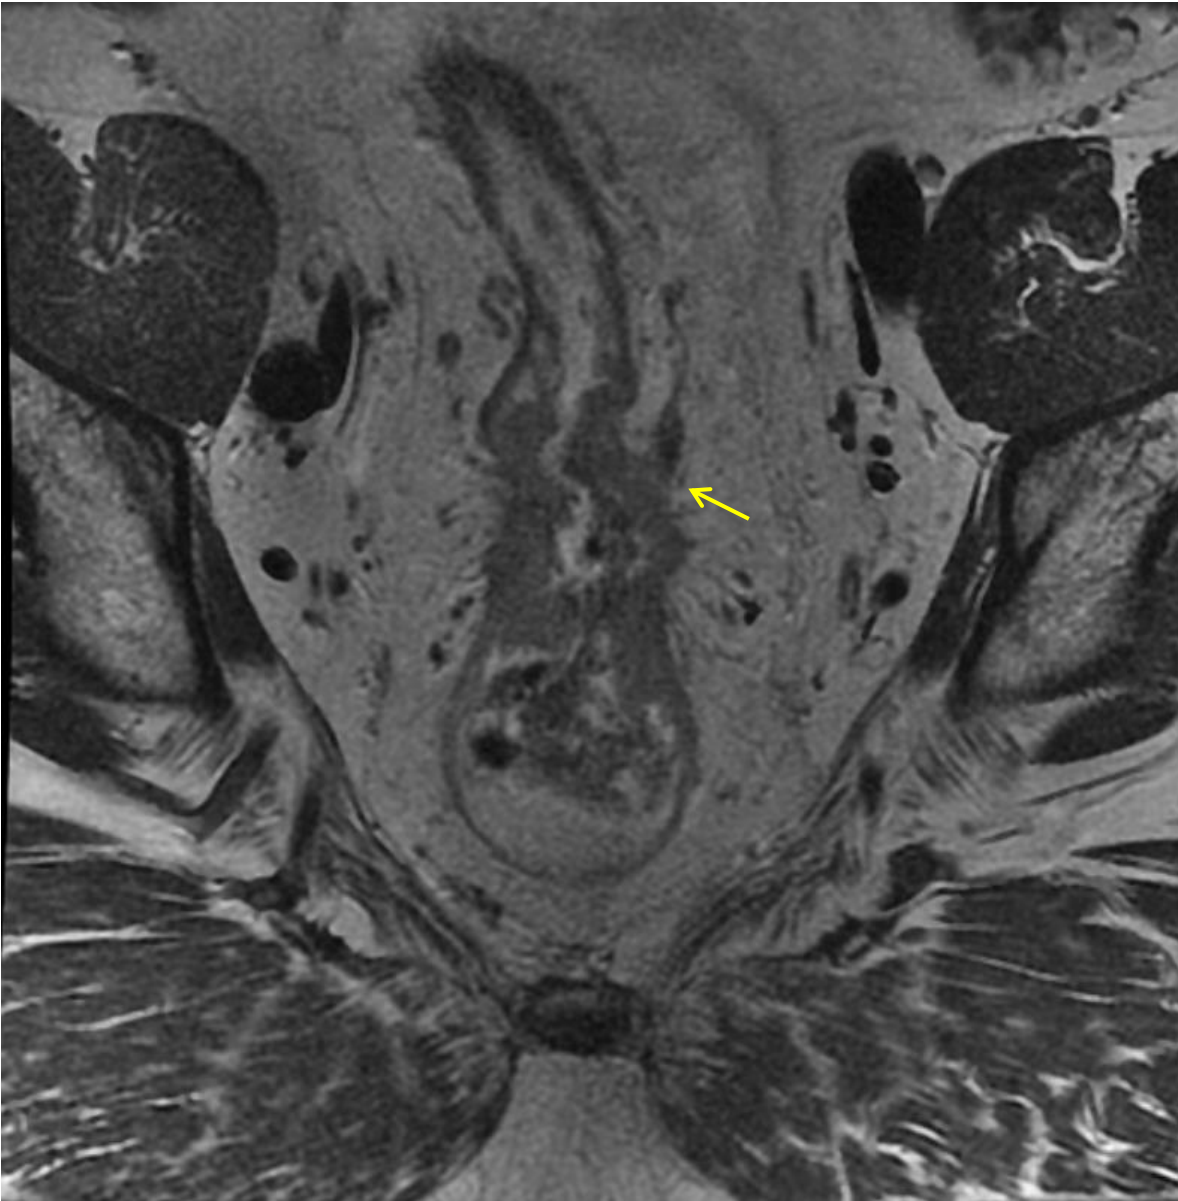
(Case 201) Coronal MRI images of a 56-year old male patient with a locally advanced mid- to upper rectal cancer staged cT4aN1b, with extramural venous invasion (yellow arrow)
